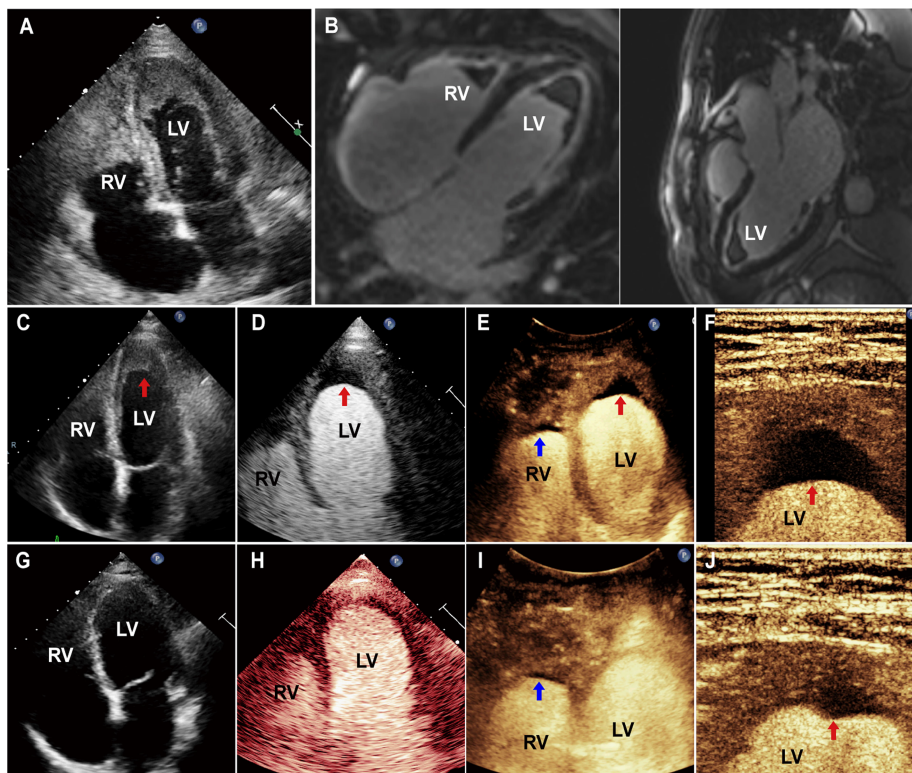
(A) and (B) Transthoracic echocardiography and cardiac magnetic resonance showing obliteration of the biventricular apex with mural thrombi on admission. Echocardiographic images at the 2-month follow-up: (C) 2D-TTE showing a large thrombus in the LV apex (red arrow). (D) Contrast echocardiography with the phased array probe depicting a filling defect in the LV apex (red arrow). (E) The imaging with the convex array probe reveals filling defects in biventricular apex (arrows). (F) The imaging with the linear array probe clearly shows the LV thrombus (red arrow). Echocardiographic images at the 6-month follow-up: (G) and (H) 2D-TTE and contrast echocardiography with the phased array probe showing no abnormal echogenic organized layer in biventricular apex. (I) The imaging with the convex array probe reveals a linear filling defect in the RV apex (blue arrow). (J) The imaging with the linear array probe shows a minor filling defect in the LV apex (red arrow). LV, left ventricle; TTE, transthoracic echocardiography.
